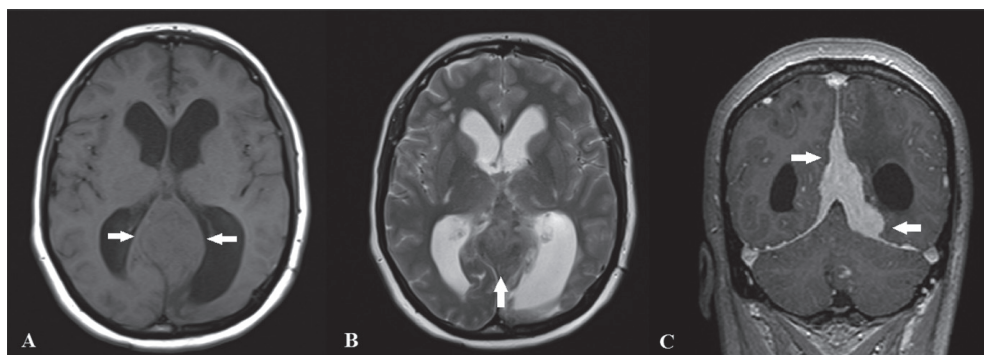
Magnetic resonance imaging revealed a mass on the tentorium (arrows) caused by histoplasmosis that shows iso/hypointensity on T1- and T2-weighted images (A and B, respectively) with exuberant contrast enhancement on a gadolinium-enhanced, T1-weighted image (C).
